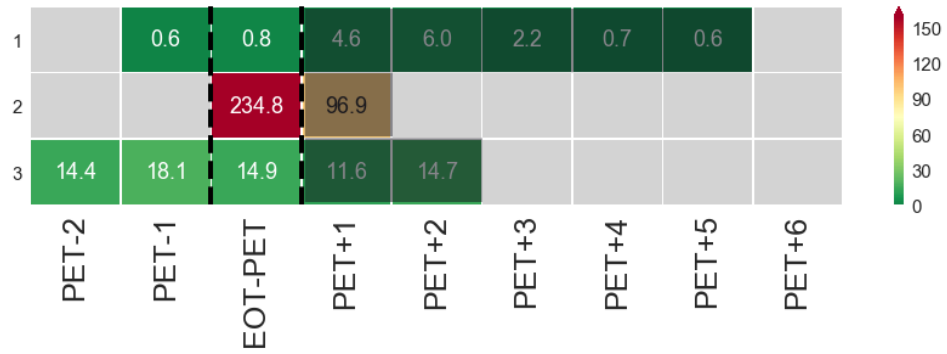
Metabolic tumor volume in positive EOT FDG-PET non-progressing NCI patients.
